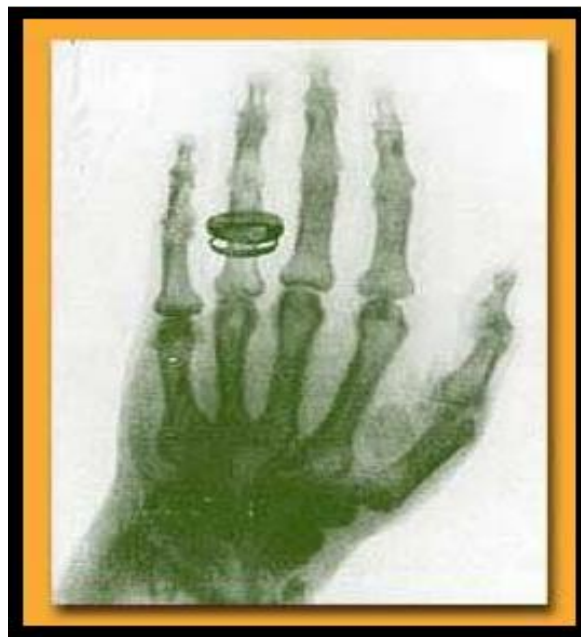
Roentgen's wife hand. (rudaw.net 2015)
